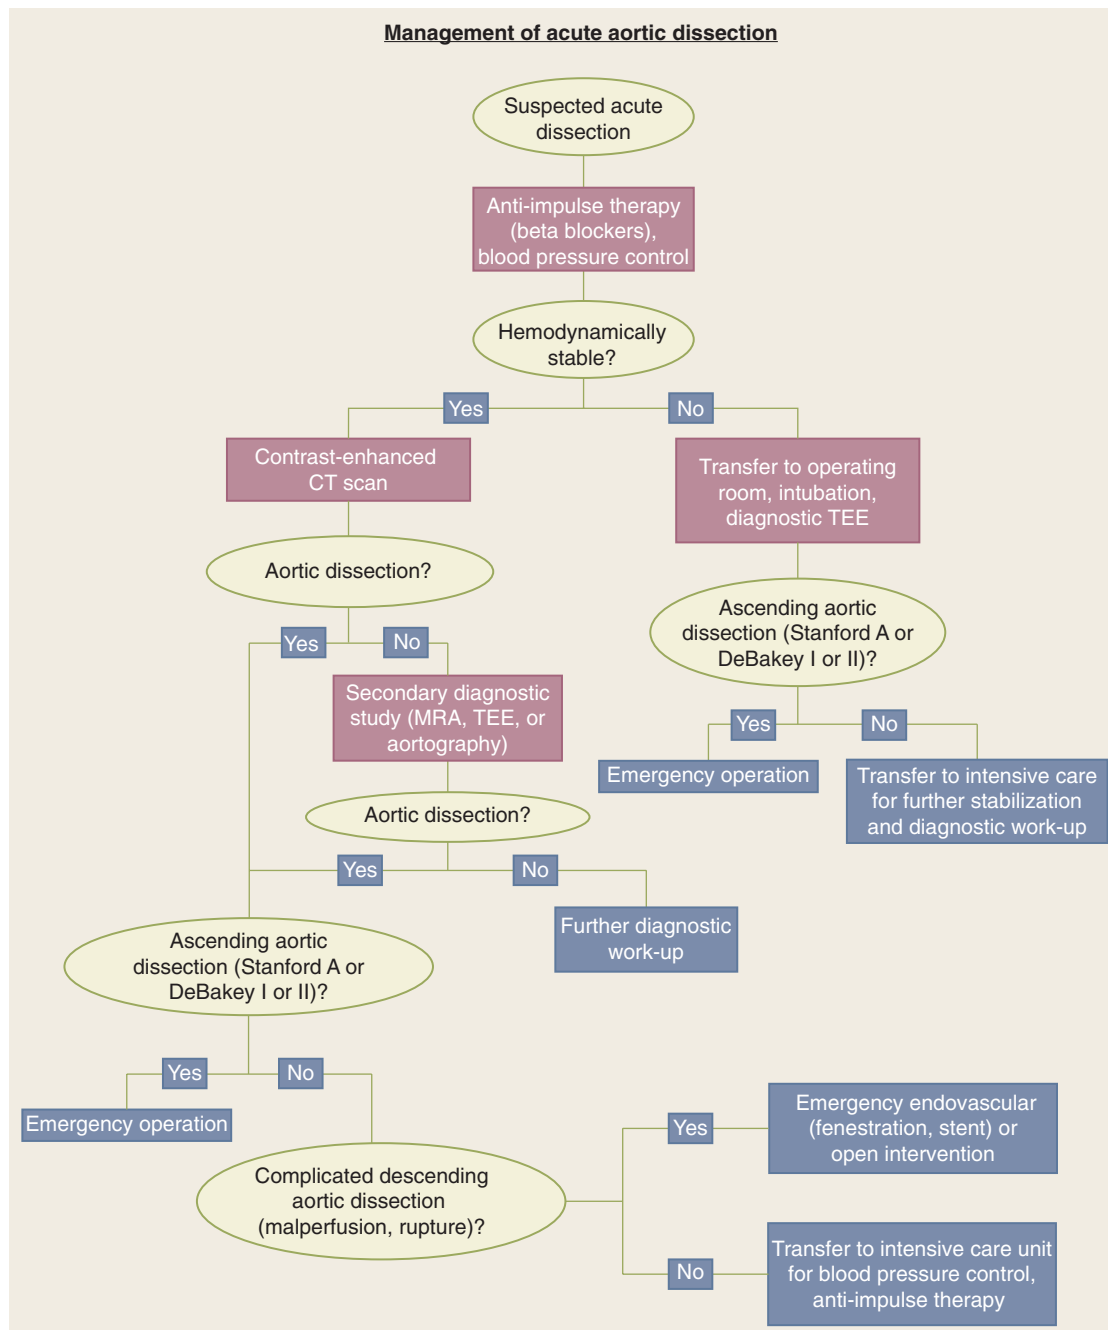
Algorithm used to facilitate decisions regarding treatment of acute aortic dissection. CT = computed tomography; MRA = magnetic resonance angiography; TEE = transesophageal echocardiography.
